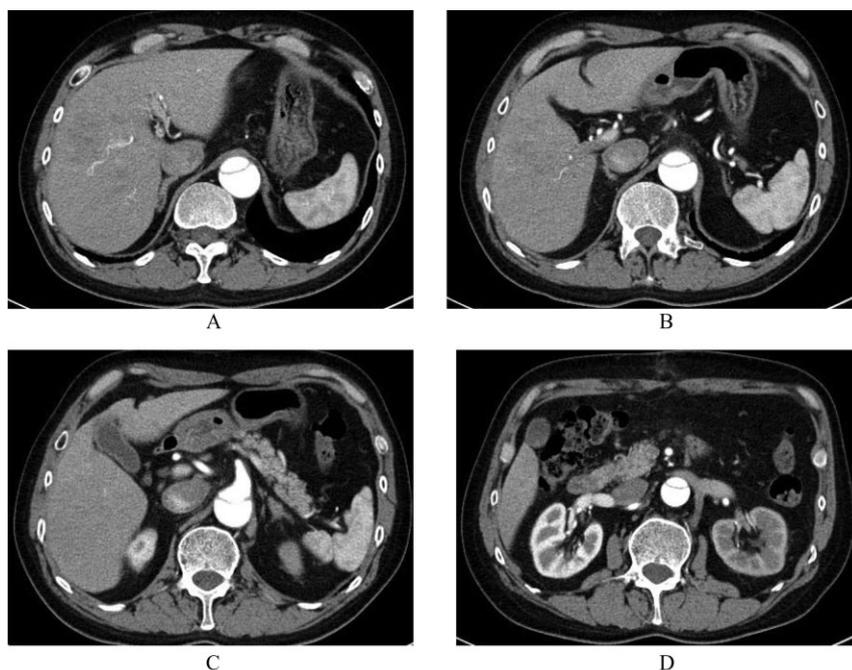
Postoperative abdominal computed tomography in a 56-year-old man with delayed visceral organ ischemia, induced by a type B acute aortic dissection, treated by emergency fenestration. The intimal flap is visualized in the abdominal aorta (A–D). The true lumen is patent, and blood flow to the spleen is clearly visible (A–C). Blood flow to the left kidney is diminished (D).
